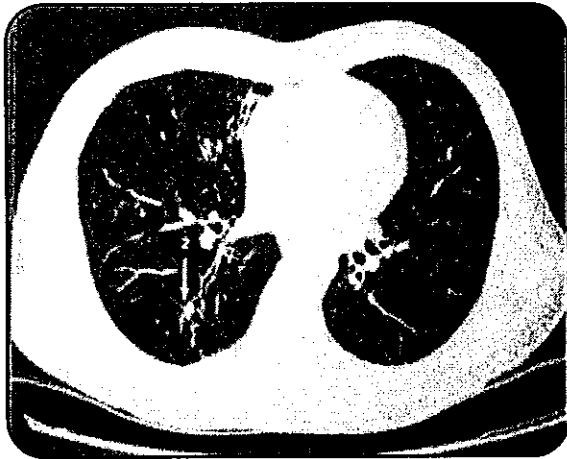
High resolution CT pointing to a small nodule, a few dilated bronchioles on the right lower zone can be appreciated.
